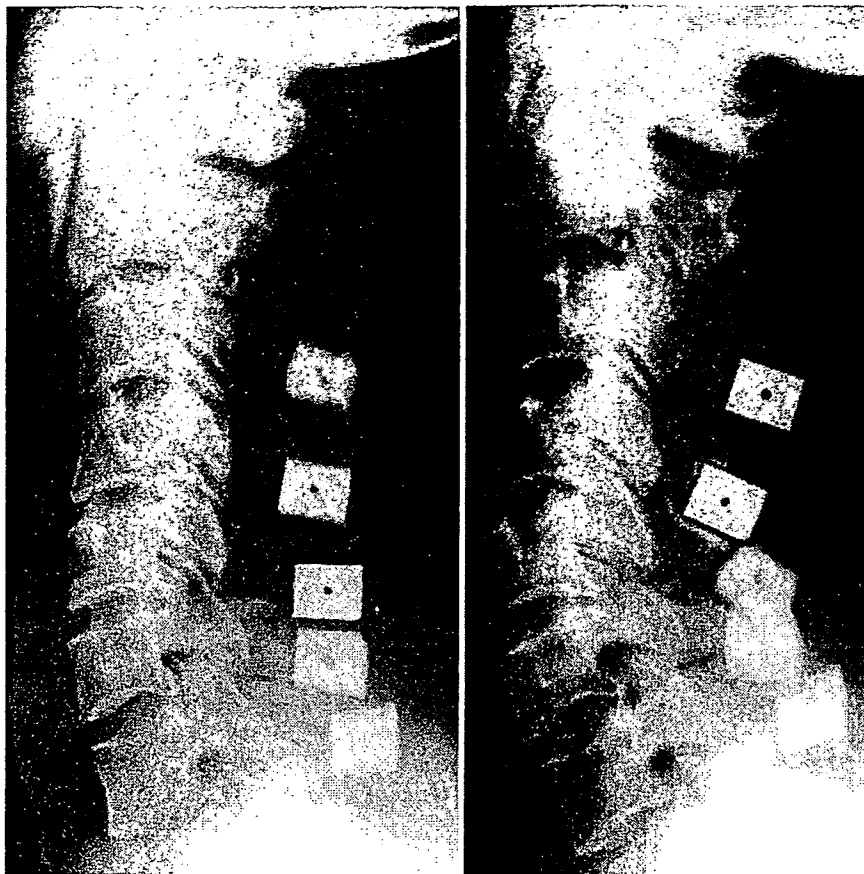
Case 2. Radiographs obtained 1 year (*left*) and 4 years (*right*) after laminoplasty. This patient had undergone spinous process-splitting laminoplasty in which hydroxyapatite intraspinal spacers were implanted from C-3 to C-7. At 4 years postoperatively, radiographs showed that the spacer of C-4 and C-5 was dislocated.
